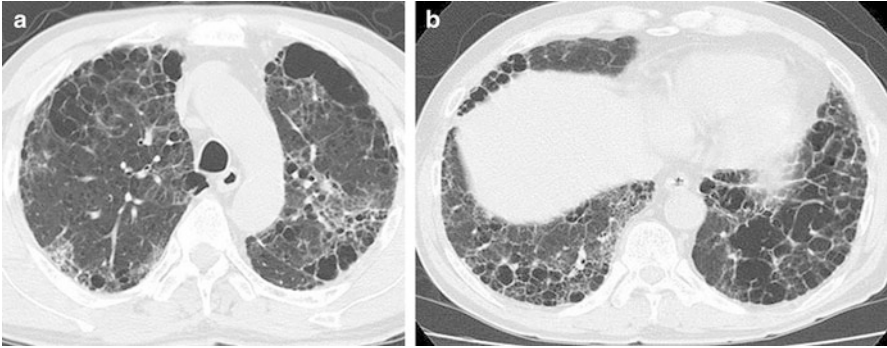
Pulmonary fibrosis concomitant with pulmonary emphysema. (a) Computed tomography (CT) of upper lung shows paraseptal and centrilobular emphysema mixed with ground-glass opacity and reticular opacity. (b) CT scan of lower lung shows multiple cysts including large thick-walled cysts that mimic honeycombing
